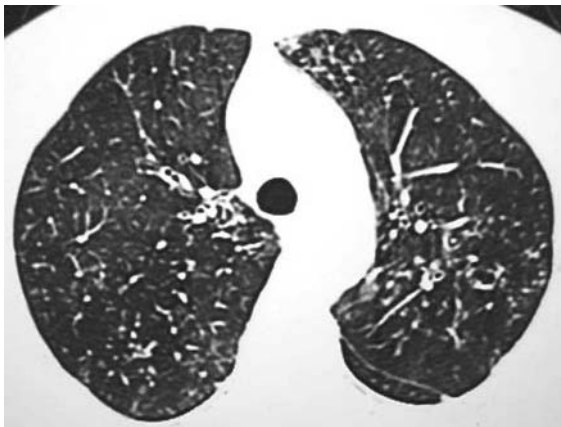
Asymptomatic 55-year-old woman with primary Sjögren's syndrome. High resolution CT scan obtained at the level of the lower lobes shows, in the periphery of the lung, focal areas of bronchial wall thickening, with characteristic tree-in-bud appearance and sparse peribronchial nodules (courtesy of Dr K. Malagari).
